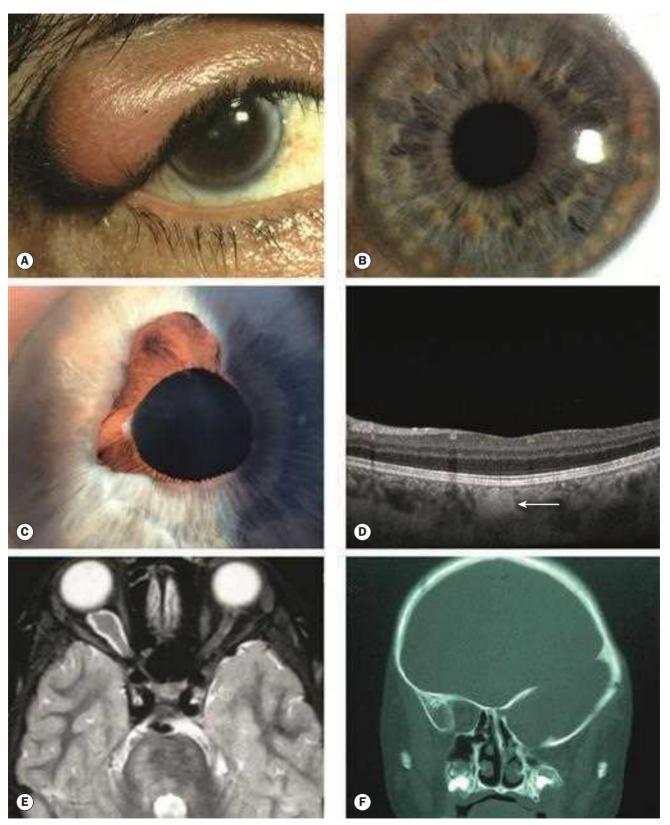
Ocular features of neurofibromatosis type I. (A) Nodular plexiform neurofibroma of the eyelid; (B) Lisch nodules; (C) congenital ectropion uveae; (D) OCT showing choroidal hyper-reflective nodule (arrow). There is often a reduction in mean choroidal thickness; (E) axial STIR MR image demonstrating a right-sided optic nerve glioma. There is myelin vacuolization in the pons; (F) coronal CT image showing absence of the greater wing of the left sphenoid bone
